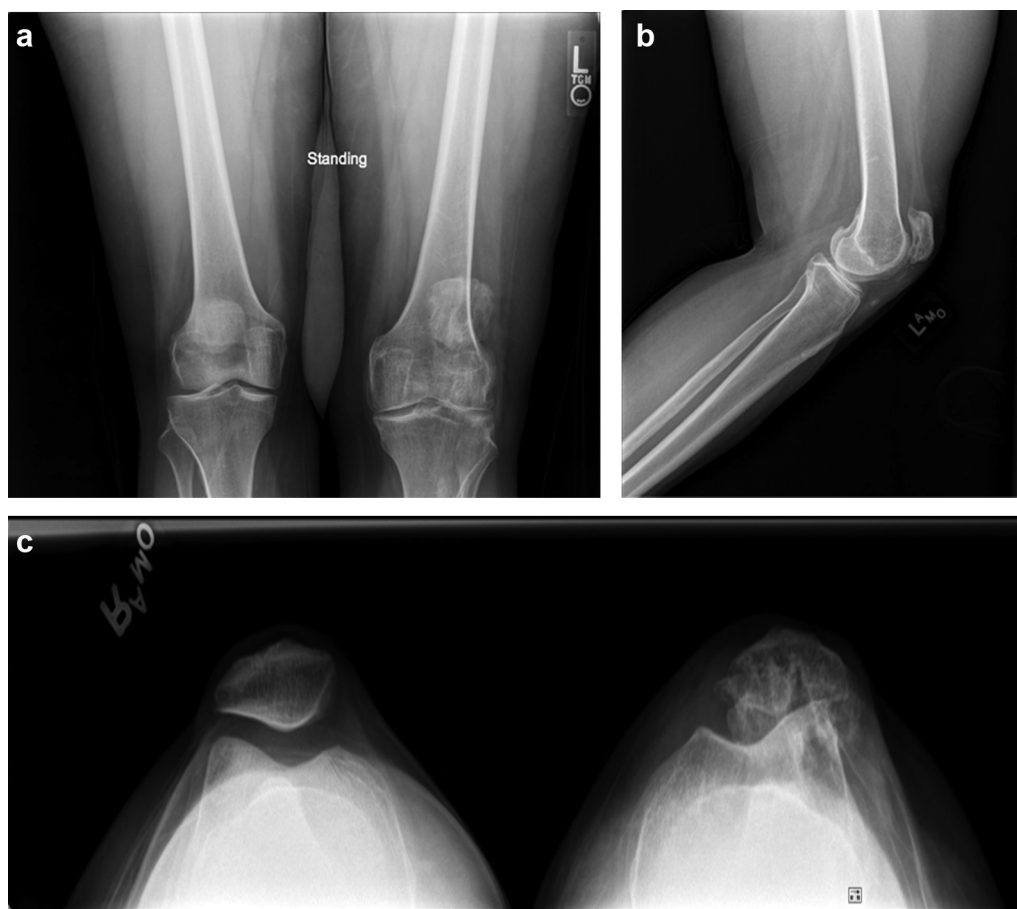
(a) Preoperative weight-bearing anteroposterior radiograph of the bilateral knees. The left knee is noted to have significant degenerative changes. (b) Preoperative lateral radiograph demonstrates patella alta. (c) Preoperative Merchant views show significant posttraumatic deformity of the left patella.
